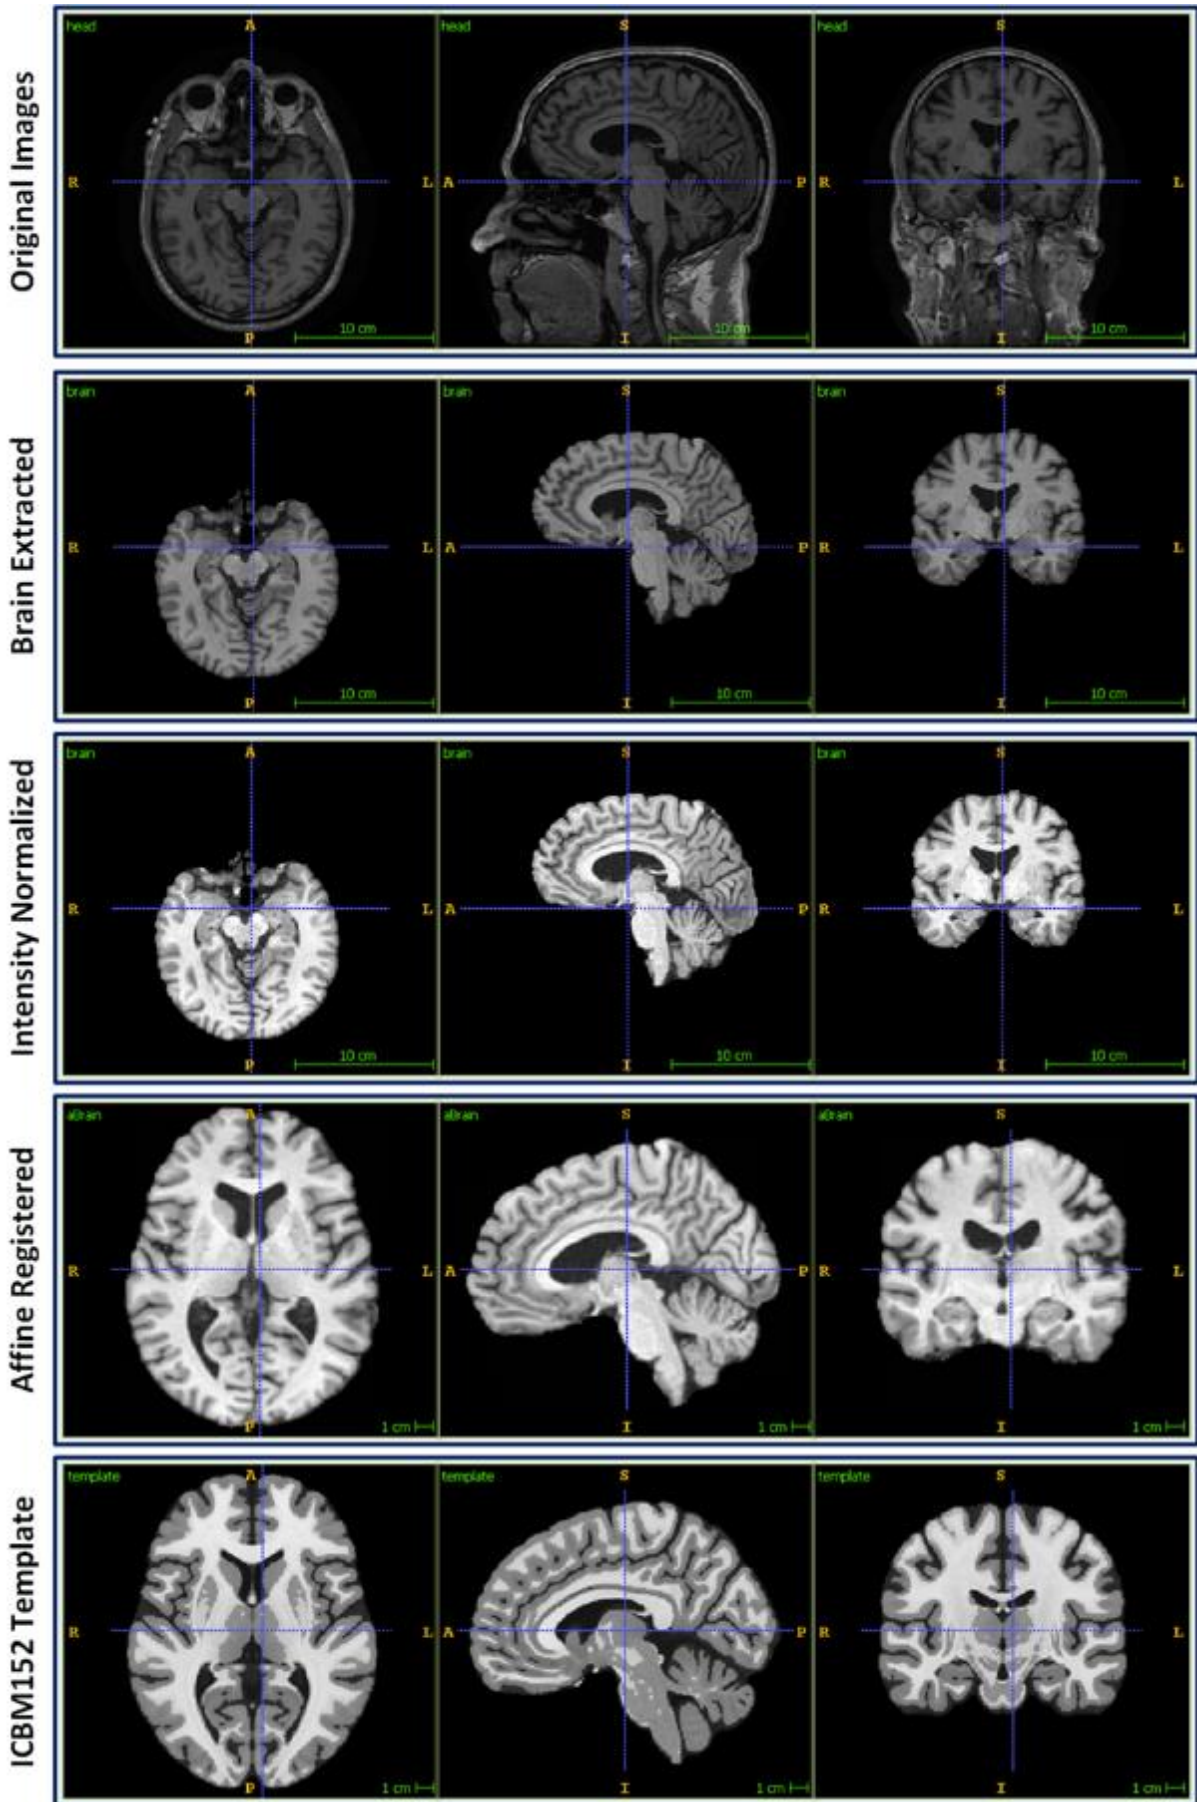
Pre-processed MR images and ICBM152 template
